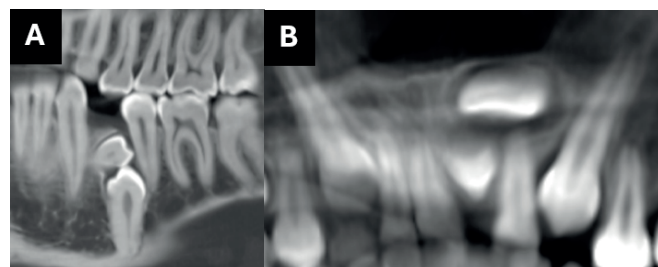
Representative CBCT images of ST-related impaction. A. Impaction of mandibular premolar teeth in the panoramic reconstruction. B. Impaction of maxillary central incisor teeth in the panoramic reconstruction.
